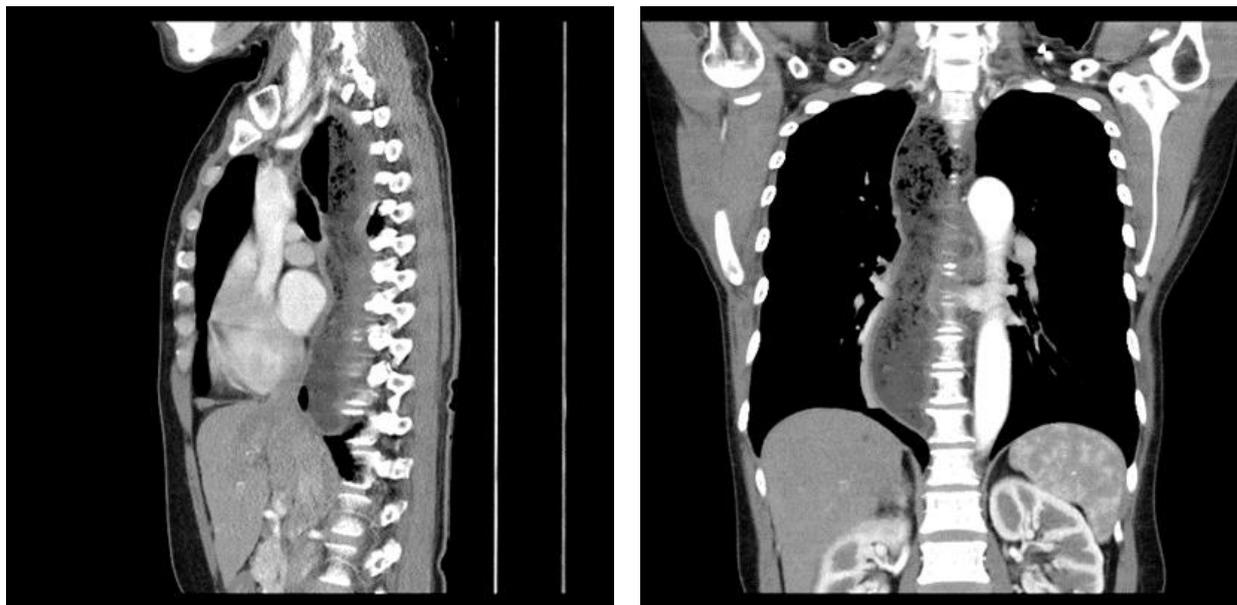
CT scan with contrast of the chest after surgery showed the esophagus was still dilated containing food material with air fluid levels
